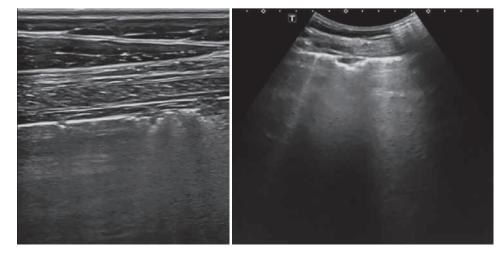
11a, b: Case 4: Ultrasonographic examination 14 weeks after starting treatment. Small nodules and comet tail artefacts still detectable. | 11a, b: Fall 4: Ultraschall Untersuchung 14 Wochen nach Therapiebeginn. Kometenschweifechos und Konsolidierung der Lunge sind noch sichtbar.
